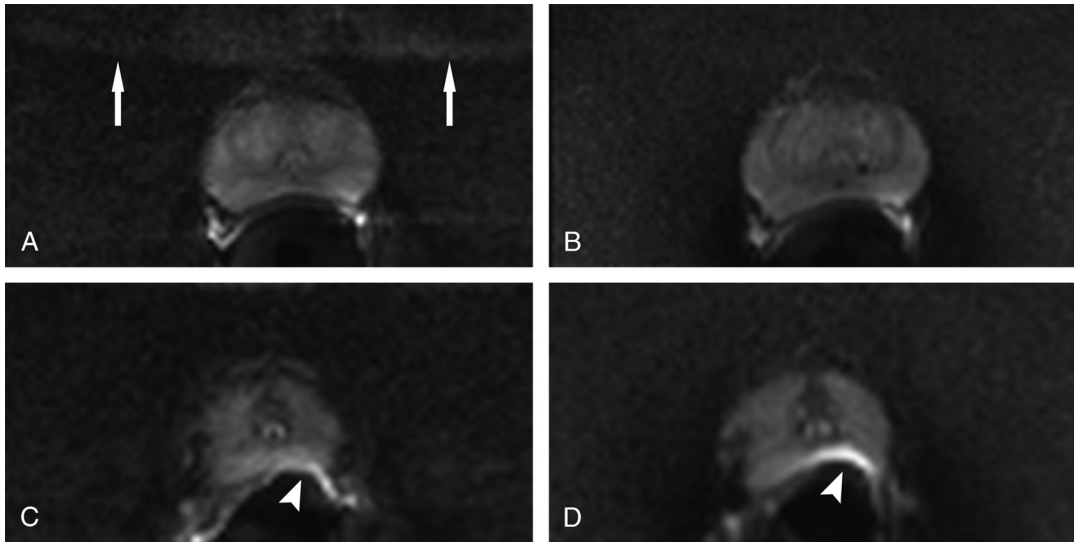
A 68-year-old male patient undergoing mpMRI of the prostate. Ghosting artifact (arrows) is present on rs-DWI b-1000 image (A) but not on reduced-FOV sTX-DWI b-1000 image (B) of the same patient at the level of the midgland. Susceptibility artifacts (arrowheads) are less pronounced on rs-DWI b-1000 image (C) than on reduced-FOV sTX-DWI b-1000 image (D) in the same patient at the level of the apex.
